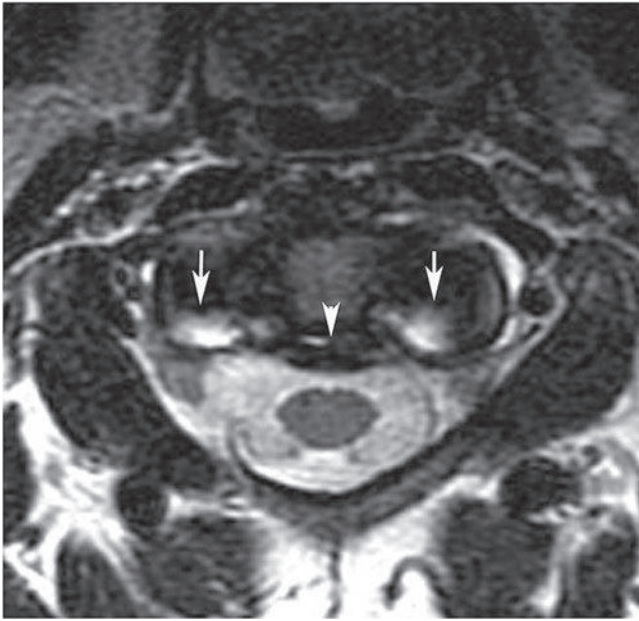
An axial T2-weighted image shows prominence and edema at the insertion site of the transverse ligament (*arrowhead*) on the lateral masses of C1 (*arrows*).
